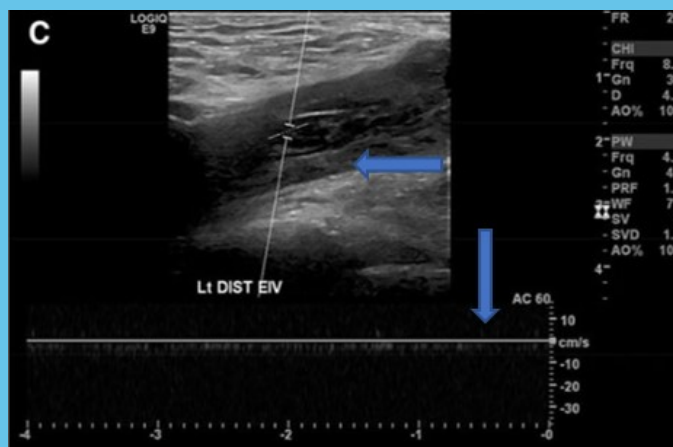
Vessel filled with mixed echogenicity material and there is essentially no color or doppler signal.
